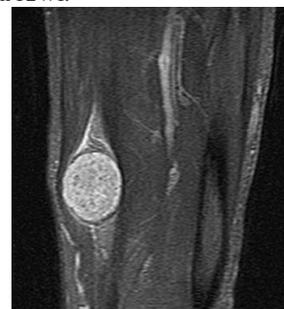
MRI showing a fusiform soft tissue mass associated with the neuro-vascular bundle.
